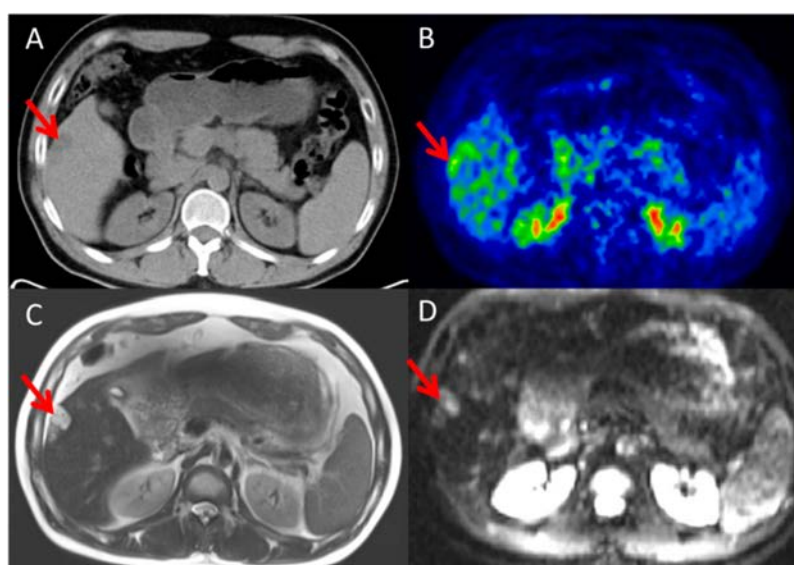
Images of a small hepatocellular carcinoma confirmed by pathology. CT (A) shows only slightly low density, and PET (B) also indicates a slightly higher metabolism than in normal tissue. However, it clearly appears in the corresponding T2MRI (C) and DW-MRI (D) images.
